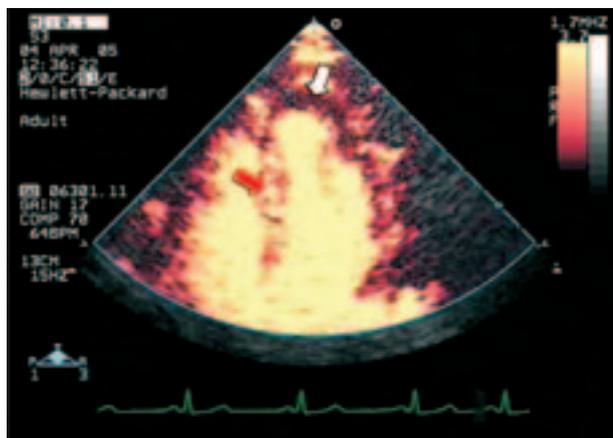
Myocardial contrast echocardiography study at rest. Example of no-reflow in a patient with ST elevation acute myocardial infarction, following primary percutaneous coronary intervention to a lesion in the mid-left anterior descending artery. The area of absence of myocardial enhancement in the apex is evident (white arrow), as opposed to the interventricular septum which is opacified (red arrow).
